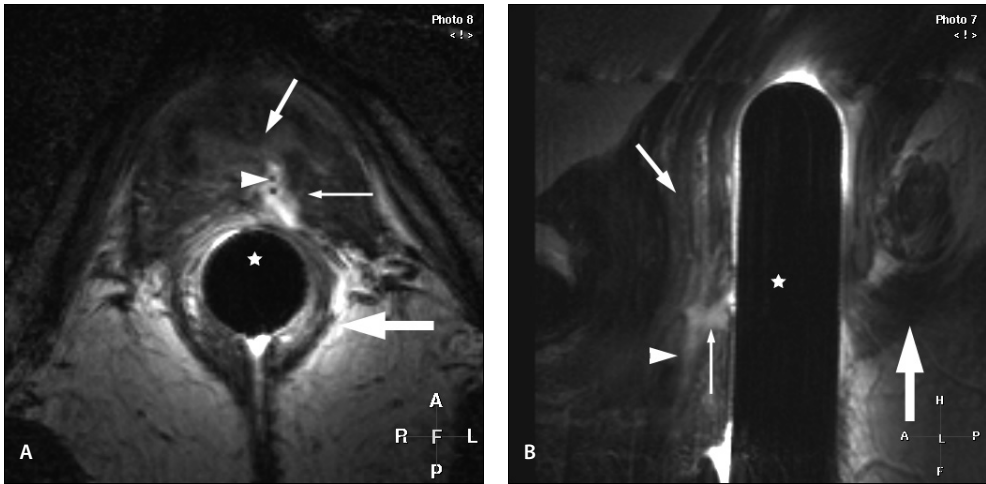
Anovaginal fistula with an additional extension between the anus and the vagina. (a) Transverse T2-weighted fast SE image (2,500/100) shows a high-signal-intensity anovaginal fistula (thin straight arrow) containing low-signal-intensity air bubbles (arrowhead). The vagina (upper arrow), external anal sphincter (thick straight arrow), and endoanal coil (★) are also seen. (b) Midsagittal T2-weighted fast SE image (2,443/100) shows the anovaginal fistula (thin straight arrow) and a part of an additional caudal extension (arrowhead). The vagina (upper arrow), external anal sphincter (thick straight arrow), and endoanal coil (★) are also shown.
